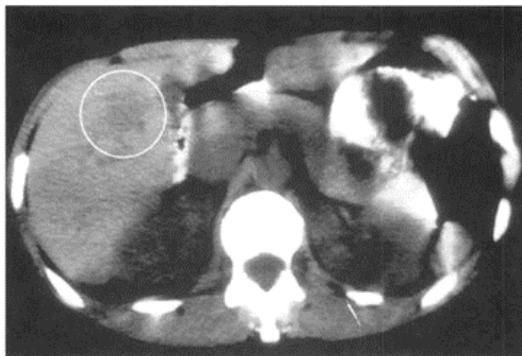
Liver CT scan showing a low-density area (circled) due to toxocariasis (Dupas et al., 1986; Ishibashi et al., 1992).
